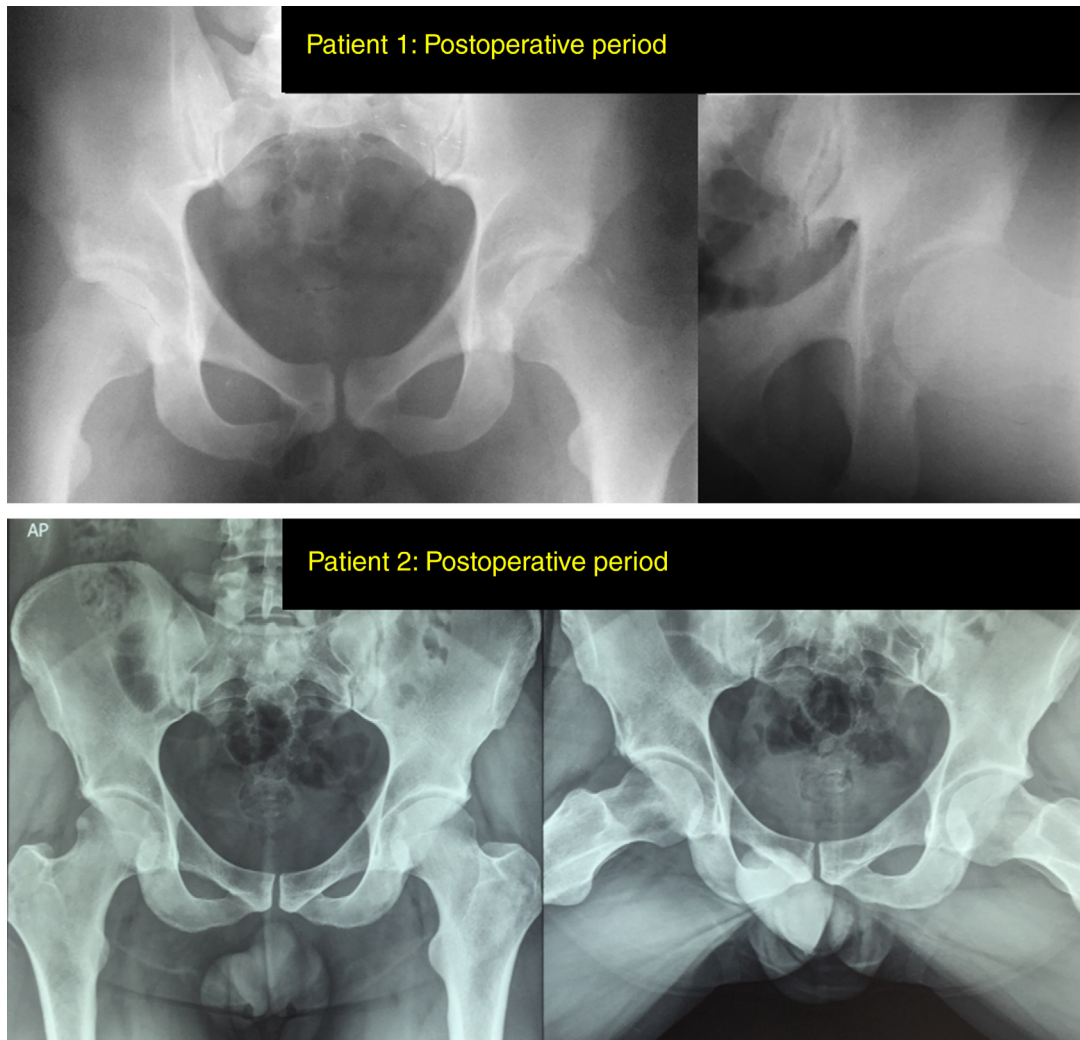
Postoperative control radiographs show a complete correction of deformities.
